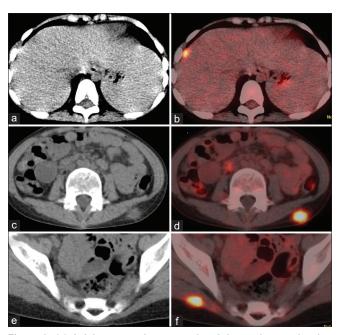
(a) Axial computed tomography abdomen image showing subcapsular hepatic deposit showing increased fluorodeoxyglucose uptake in the fused positron emission tomography-computed tomography image (b). (c) Axial computed tomography lower abdomen showing subcutaneous deposit in the left posterior lumbar region showing increased fluorodeoxyglucose uptake in the fused tomography image (d). (e) Axial computed tomography pelvis showing a hypodense lesion in the right gluteus maximus muscle showing increased fluorodeoxyglucose uptake in the fused positron emission tomography-computed tomography image (f)
